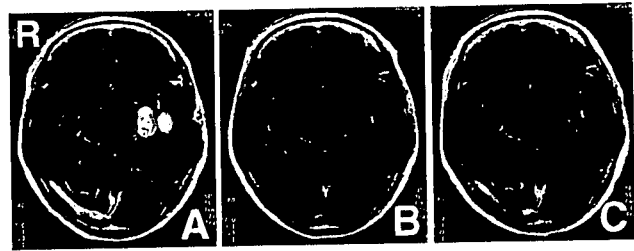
T₁-weighted magnetic resonance images with contrast medium after four cycles of rituximab showing tumor enlargement (A), after three cycles of temozolomide showing complete disappearance of the tumor (B), and after 13 cycles of temozolomide showing no signs of tumor recurrence (C).
